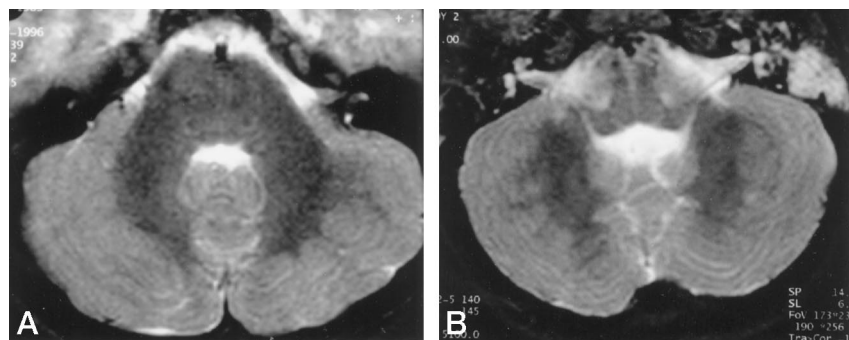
Axial T2-weighted MR images of the middle portion of the cerebellum in an 8-year-old boy (A) and in a 5-year-old boy (B) show the disorganized folia and the bumpy gray-white matter interface.
